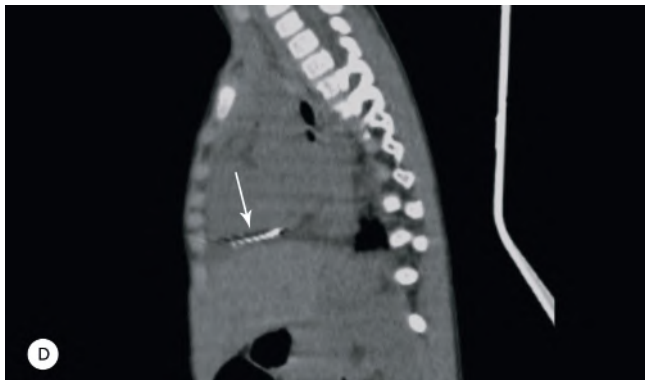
Computed tomography scans show the needle (arrow) in the lower front part of the chest (A & B). The entry point of the needle is from the fat area around the pericardium tangent to the diaphragm. A small bubble of air is seen in the anterior part of the pericardium near the right ventricle in the upper part of the needle (arrowhead) (B). Coronal (C) and Sagittal (D) views show that the needle pathway is very close to the pericardium (arrows).
